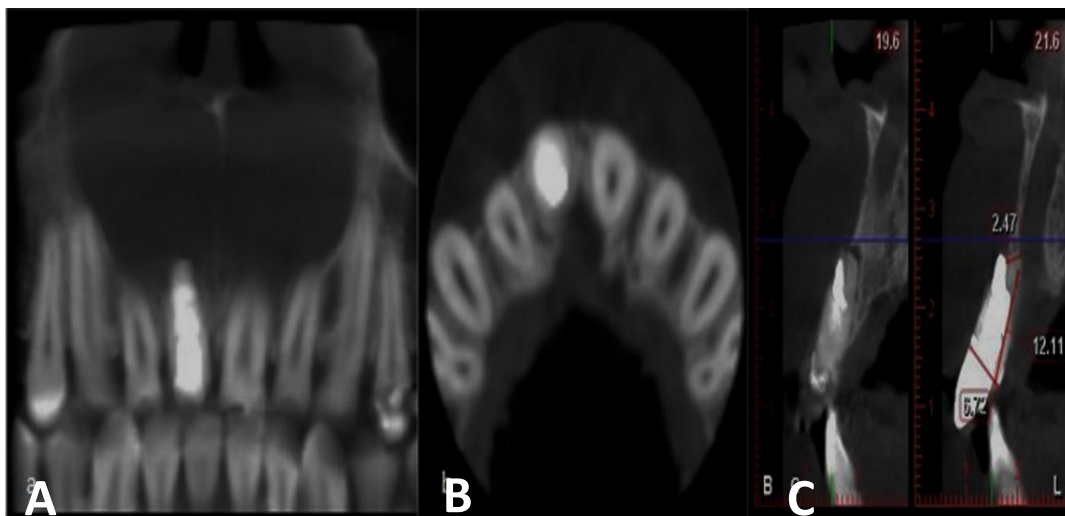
Postoperative CBCT images at 3 years and 8 months A) Coronal View B) Axial View at midroot level
